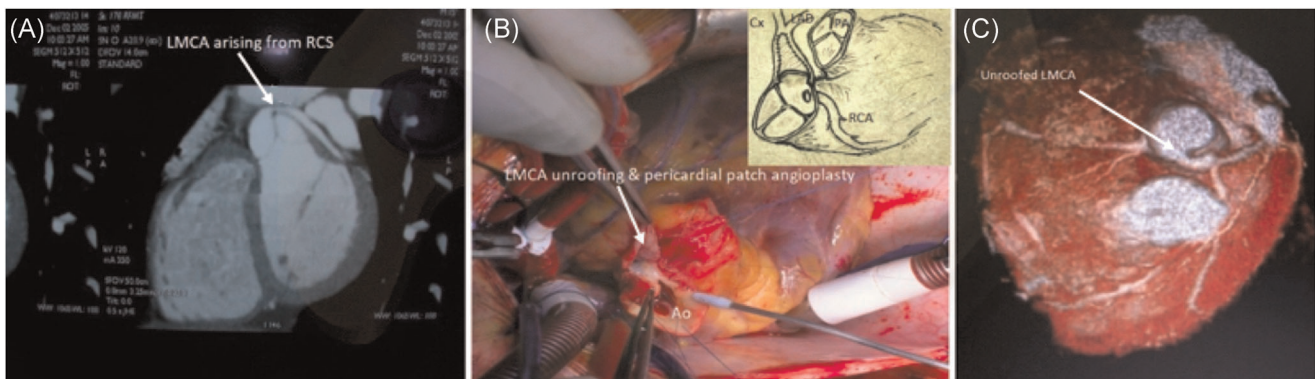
(A) Preoperative computed tomography (CT) angiography in a patient (Case 11) with a left main coronary artery (LMCA) arising from the right coronary sinus. (B) Unroofing of the LMCA and pericardial patch angioplasty. (C) Postoperative control CT angiography
